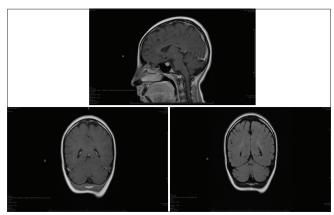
Follow-up brain MRI showing interval resolution of previous findings
